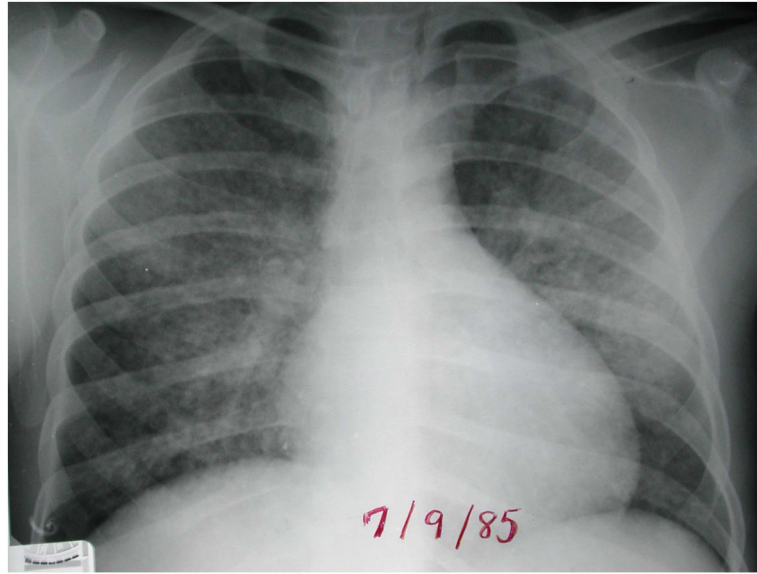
Chest radiograph of an HIV-infected patient with disseminated histoplasmosis demonstrating diffuse interstitial opacities. Courtesy of Laurence Huang, MD; used with permission.
